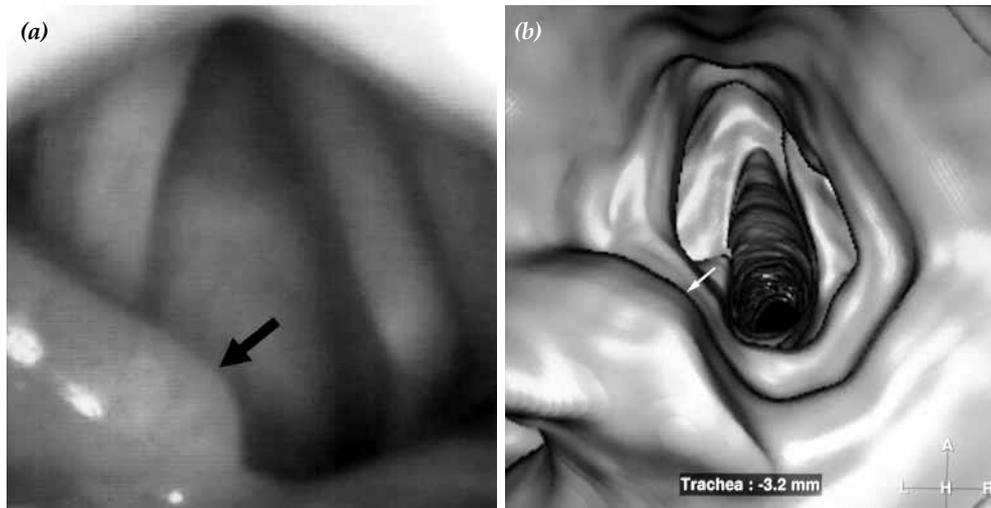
Patient with supraglottic larynx carcinoma (arrows). (a) Rigid telescopic videolaryngoscopy image. (b) Computed tomography virtual laryngoscopy view from superior aspect.
